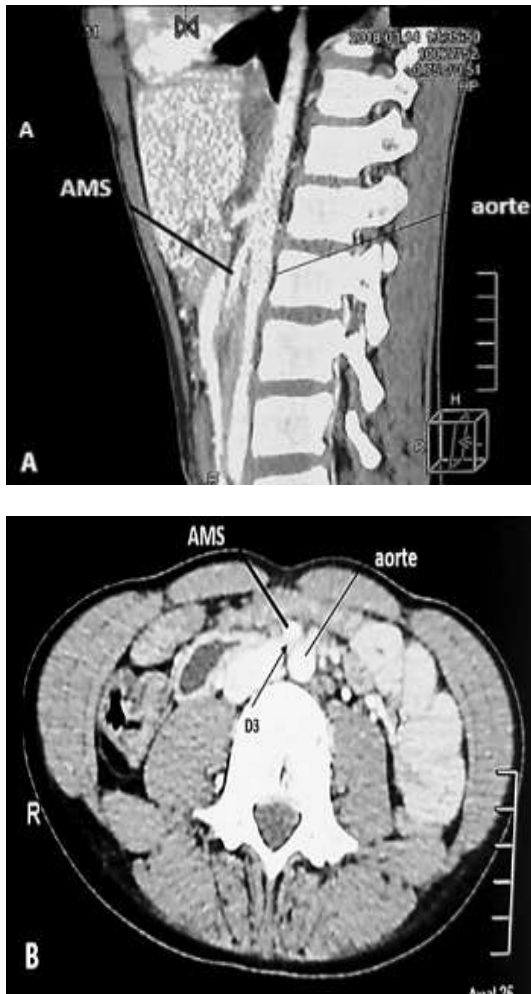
Abdominal CT scan: Sagittal view showing a narrowing of the Aorto-Mesenteric angle (2-A), transversal view through the third portion showing a duodenal D3 compression, SMA and Aorta (2-B)
